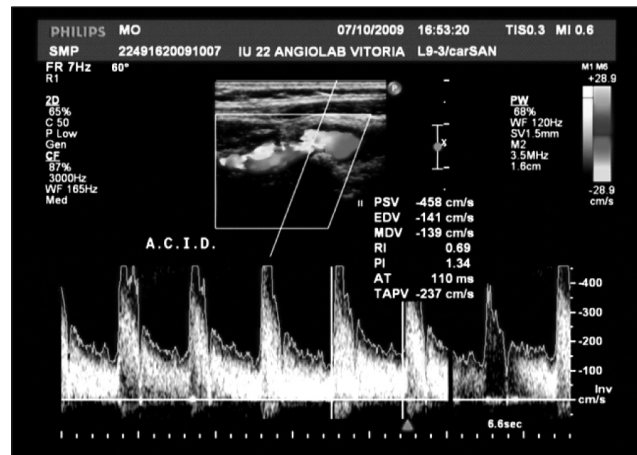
Duplex Doppler imaging showing high velocities at the point of peak stenosis of the proximal internal carotid that confirm anatomical findings.
